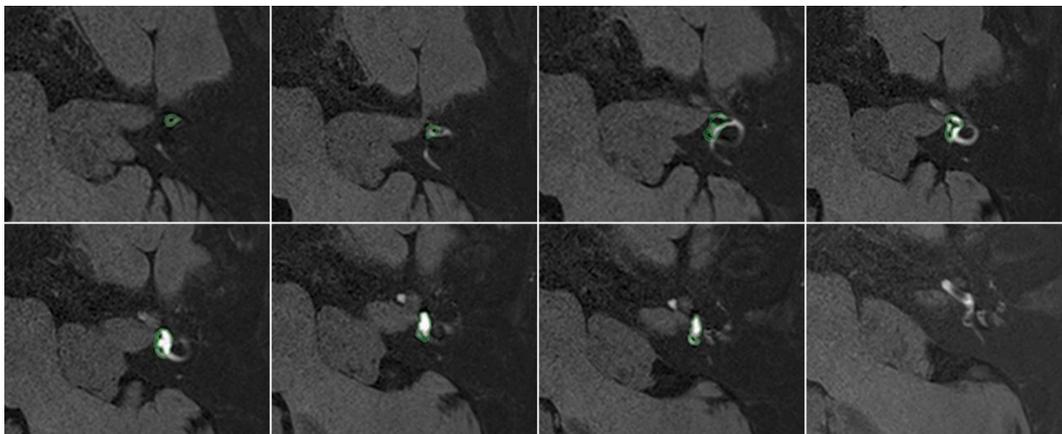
The process of contouring the ROIs on the 3D-FLAIR MR images to draw the borders of the vestibule and endolymph. All visible vestibular slices were contoured.
